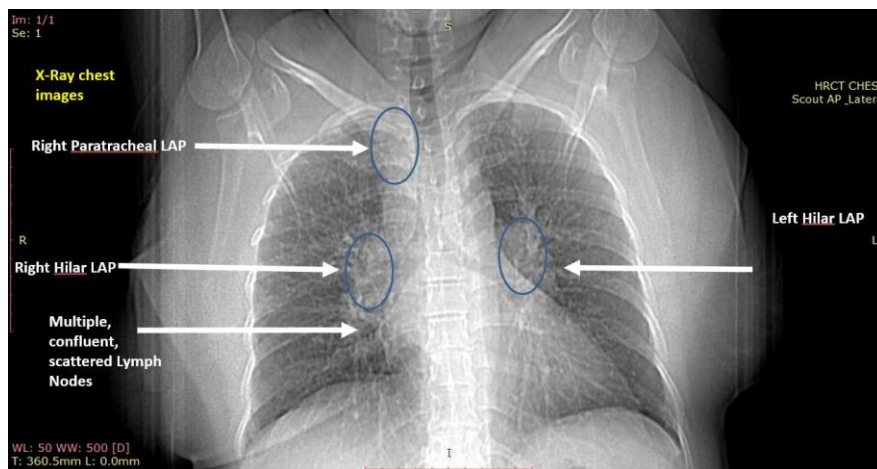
X-ray chest (AP view) showing increased hilar mass with enlargement of right paratracheal, right and left hilar lymph nodes.
